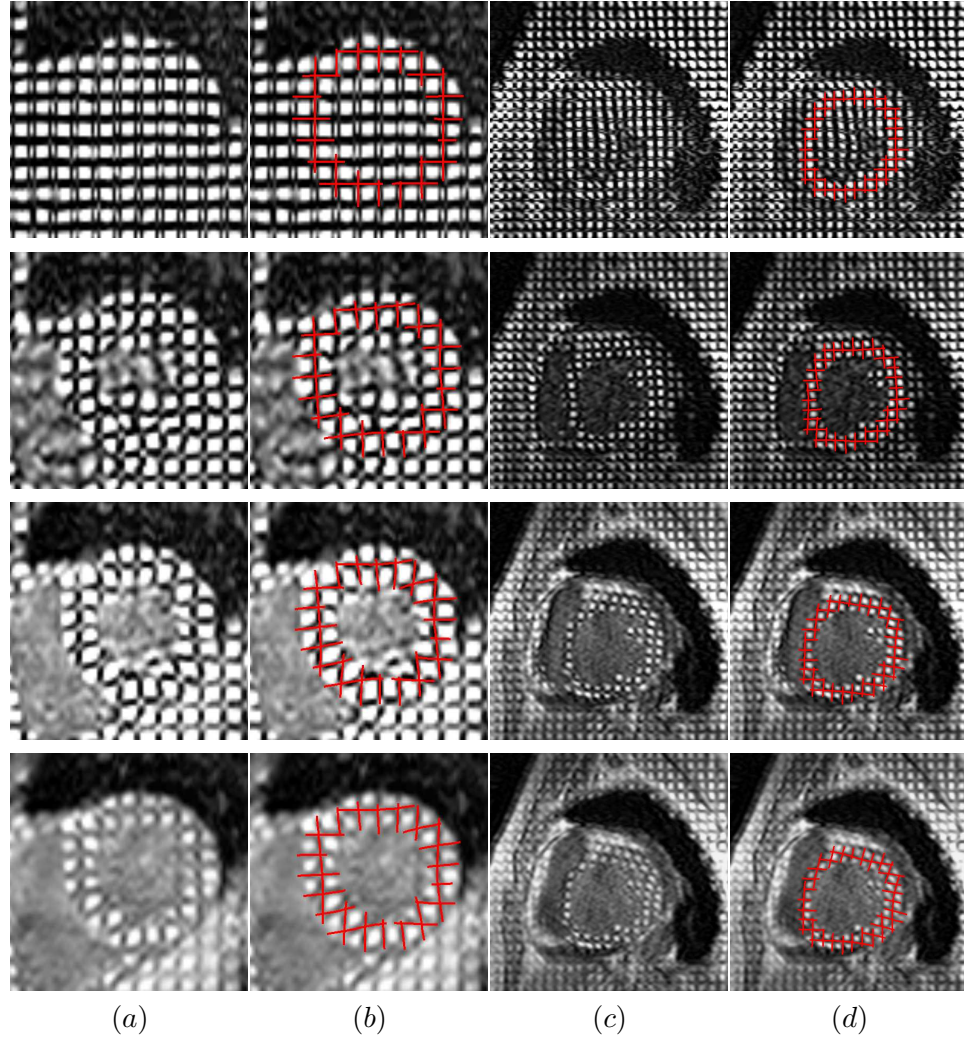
A short axis slice from the tagged cine MRI scan is shown over the cardiac cycle (first row: ED, third row: ES) for (a) a normal subject and for (c) a patient. The same slices overlaid with virtual tag lines are shown in (b) and (d), respectively. The virtual tag lines were generated by applying the deformation recovered from the anatomical scan to the manually positioned tag planes at ED.
